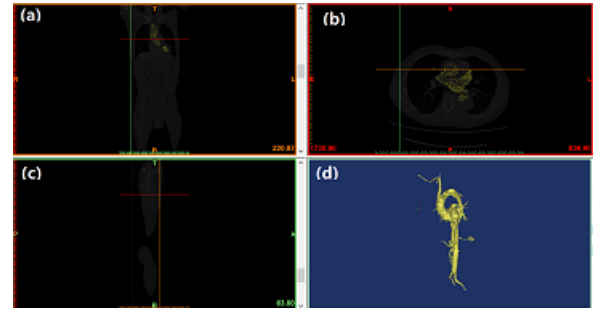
A contrasting experiment with CT images and 3D visualization image.
